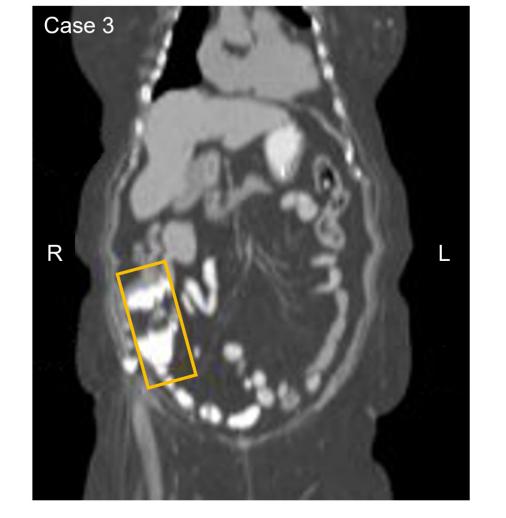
CT scan images highlighting key findings in three cases
